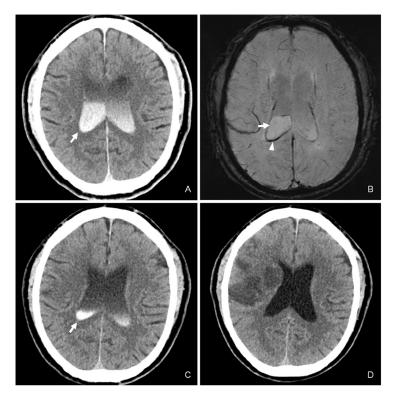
Immediate computed tomography (CT) after intravenous thrombolysis shows the fluid collection with hyperintensity (arrow) in the dependent portion of both lateral ventricles (A). The fluid collection (arrow) is not demonstrated as a dark signal, and a thin low signal (arrowhead) is observed along with the rim of the right lateral ventricle on susceptibility-weighted imaging (B). The hyperintensity (arrow) in lateral ventricles is rapidly decreased on the second followup CT (C). The final CT shows no hyperintensity in lateral ventricles (D).
